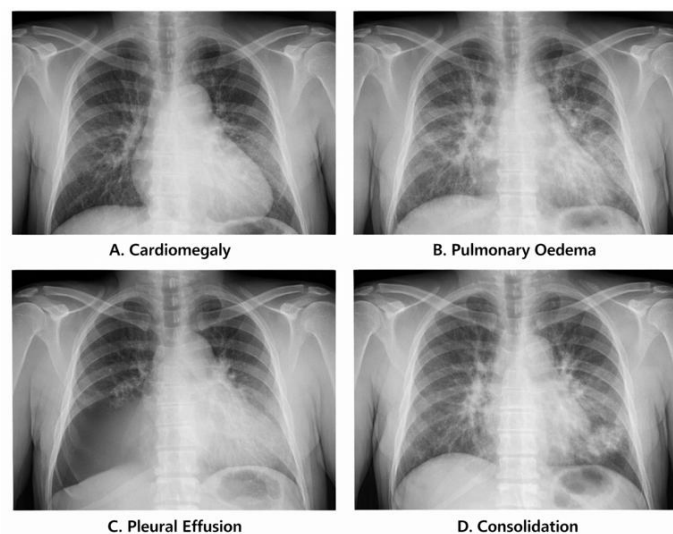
Representative chest X-ray findings in patients on maintenance haemodialysis
